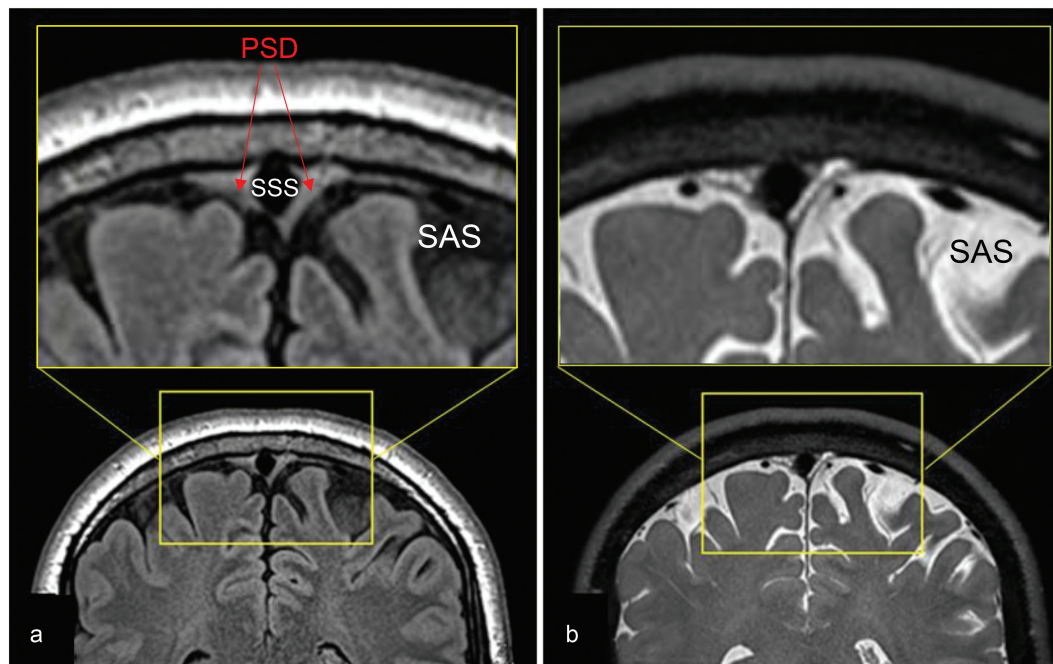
T2-weighted FLAIR and T2-weighted 3D cSSFSE of a healthy male adult, age 42. Top enlargement of the yellow box. (a) FLAIR image depicts hypointense CSF in the SAS and intermediate hyperintense PSD. (b) 3D cSSFSE image depicts hyperintense CSF in SAS and intermediate hyperintense PSD. CSF, cerebrospinal fluid; cSSFSE, centric k_y - k_z single-shot fast spin echo; FLAIR, fluid attenuated inversion recovery; PSD, parasagittal dura; SAS, subarachnoid space.
